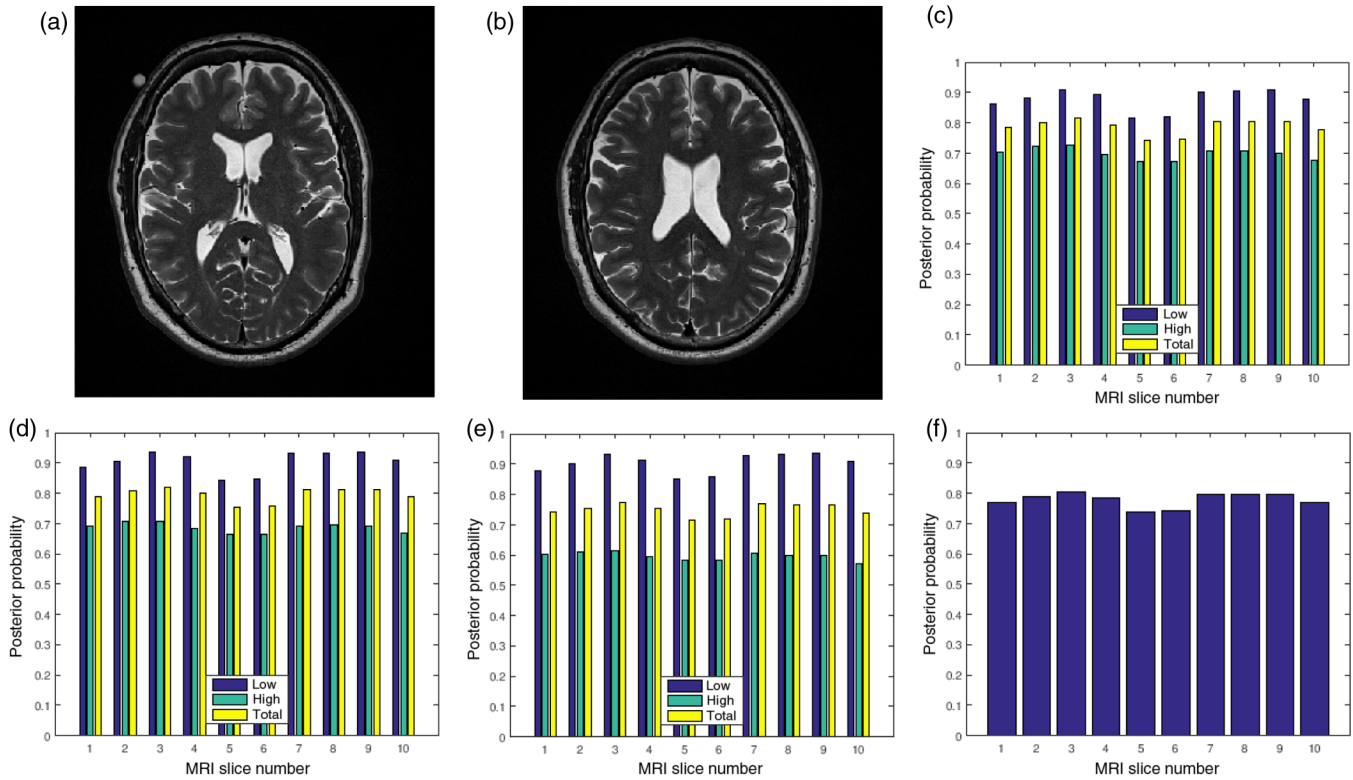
Two slices (a) slice number 1 and (b) slice number 5 in a T2 MRI volume data from BrainCare Oy, (c) contrast attribute quality scores, (d) standard deviation attribute quality scores, (e) sharpness attribute quality scores, and (f) global quality scores for 10 successive slices in the MRI volume data.
